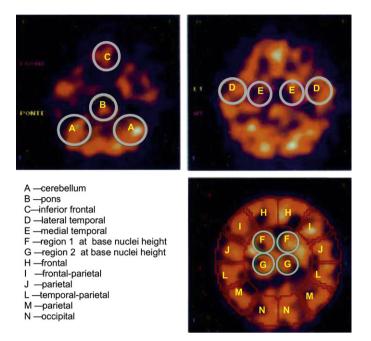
Regions analyzed by single photon computerized tomography (SPECT).
